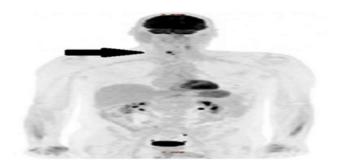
PET-CT scan showing mild FDG uptake in the left neck at the site of previous neck dissection with focal FDG uptake in the lower neck at the midline, anterior to the cricoid cartilage, consistent with locally recurrent disease. PET-CT, positron emission tomography-computed tomography.
